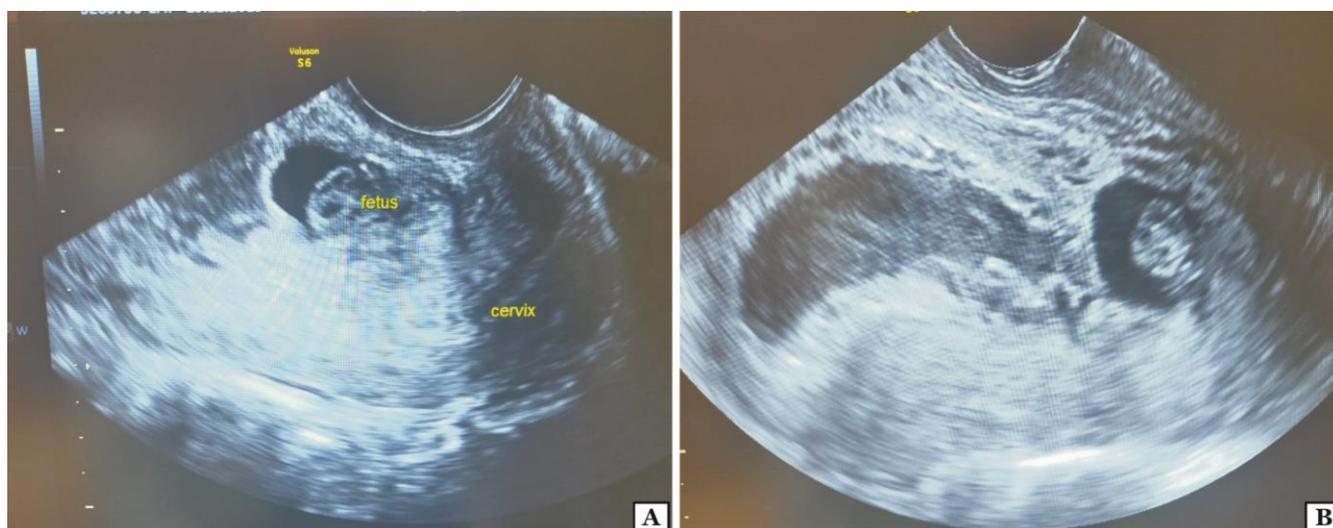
1. Transvaginal ultrasound showing (A) the empty cervical canal and the fetus in the caesarean scar. (B) empty uterine cavity.
